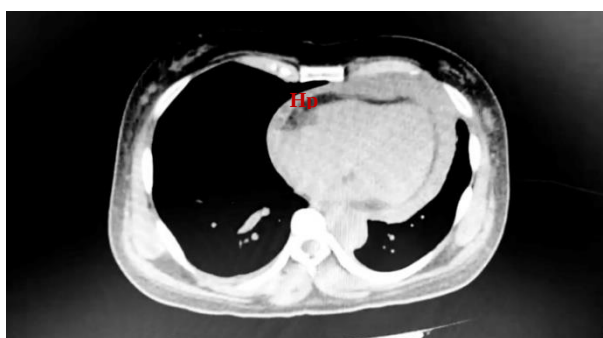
Transverse section of a plain chest CT scan.
